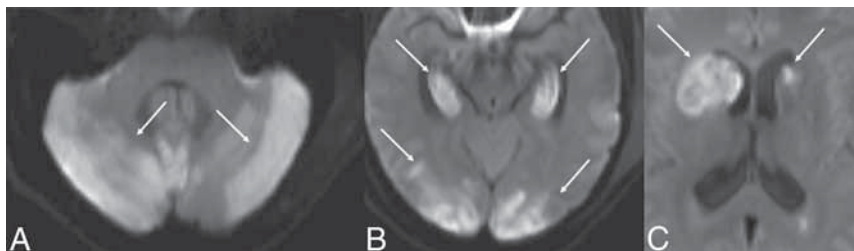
DWI of patient 3, fifty-eight hours after presentation, shows diffusion restriction in the cerebellum (white arrows, A), hippocampi and cortex (white arrows, B), and basal ganglia (white arrows, C). There is mass effect from the diffusion restriction in the right caudate nucleus on the frontal horn of the right lateral ventricle (C). The ADC map is not shown.
